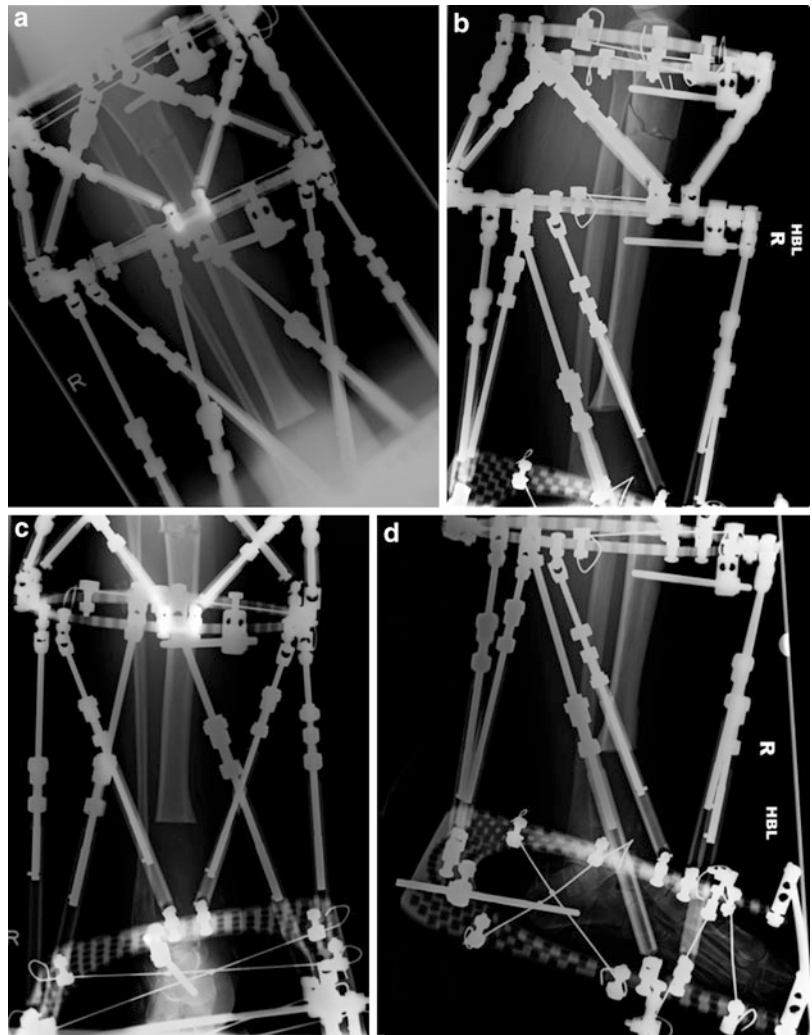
(a–d) Initial radiographs following distal tibia excision, preparation of the talar dome, and proximal corticotomy
